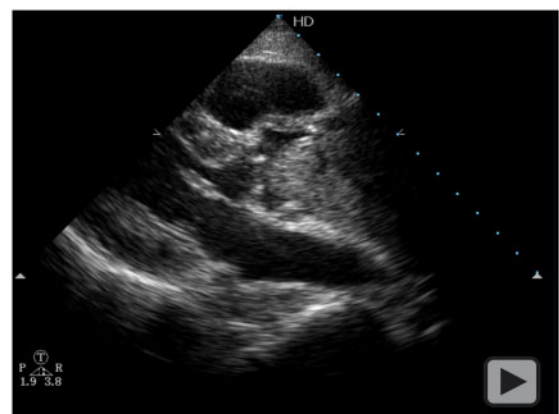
Echocardiography showed the large mass in ascending aorta.
